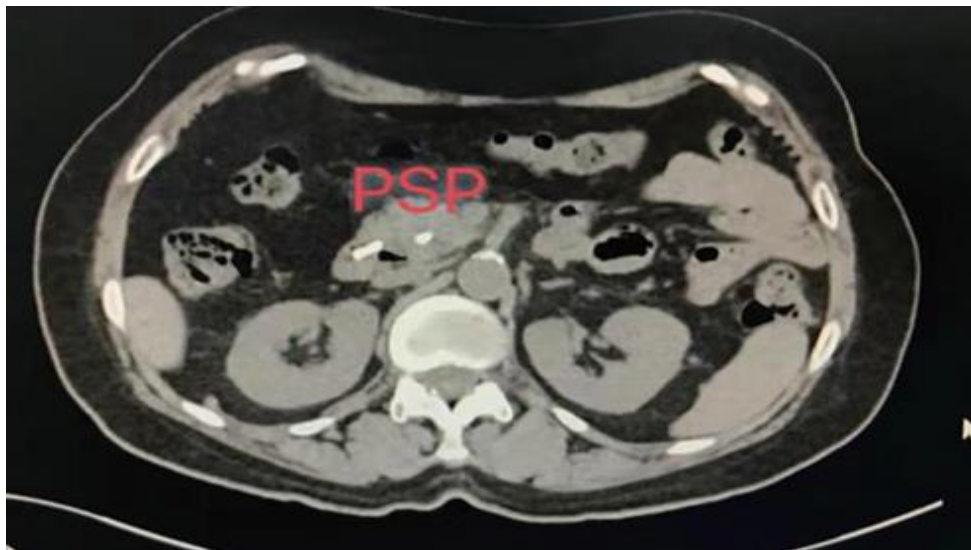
Representative CT images after pancreatic stent placement treatment.
